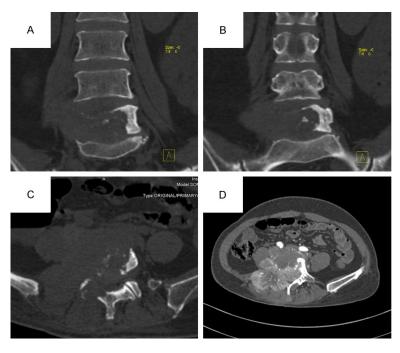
The pre-operative lumbar computed tomography (CT) scan three-dimensional reconstruction images of this patient. The pre-operative lumbar computed tomography (CT) scan three-dimensional reconstruction images (A, B: Coronal view reconstruction images; C, D: Axial view images) showed the bone destruction of the L5 vertebrae and soft tissue image around L5: this supported the diagnosis of malignancy.
